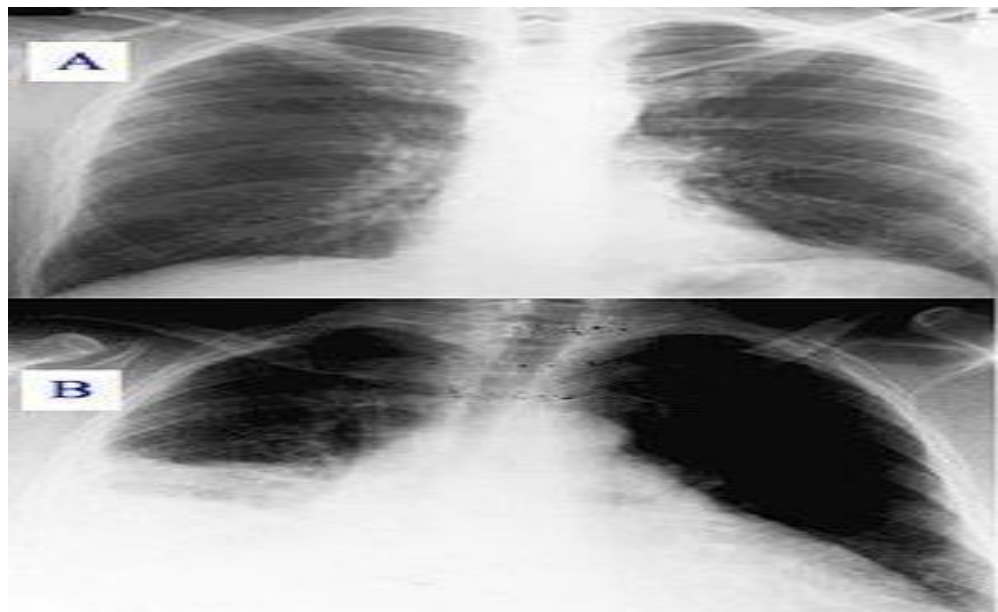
Pneumonia as seen on chest x-ray. A: Normal chest x-ray.
